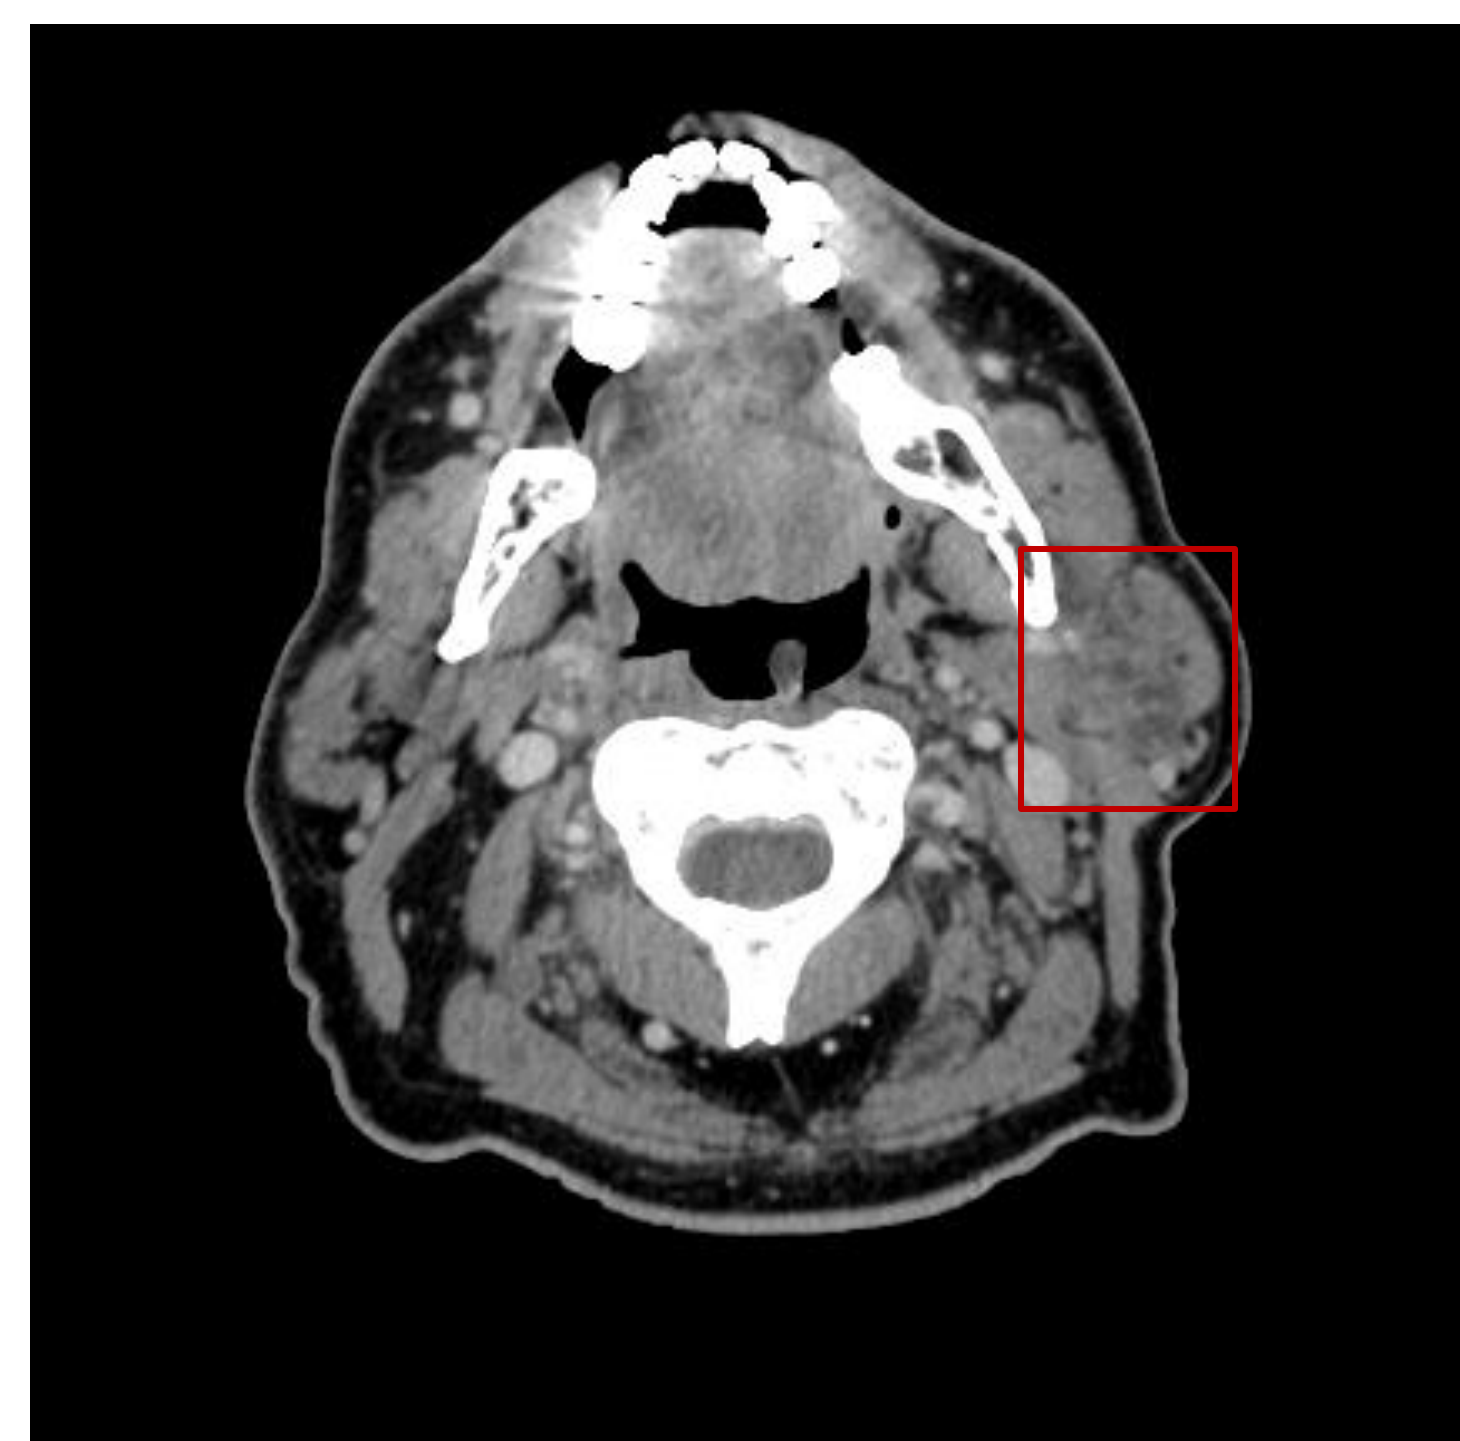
Axial CT demonstrating new 2.3 cm nodular lesion within superficial lobe of L parotid gland (19 months post-treatment)
